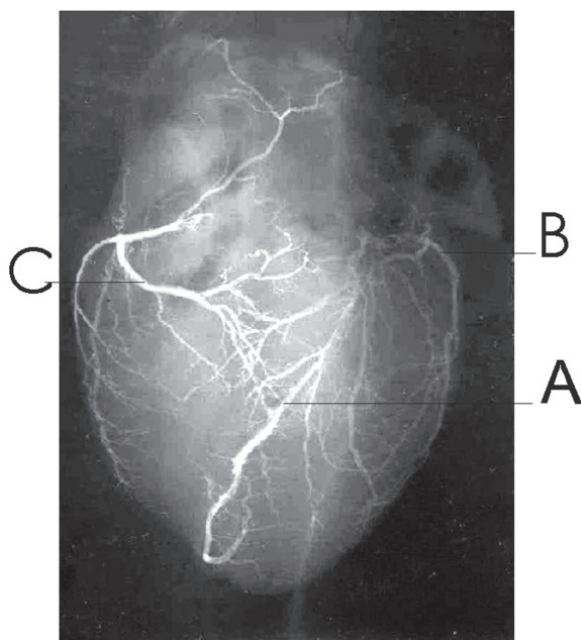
The X-ray film of coronary artery in infants; anterior position; A — anterior interventricular branch of the left coronary artery; B — circumflex branch of the left coronary artery; C — posterior interventricular branch of the right coronary artery.
